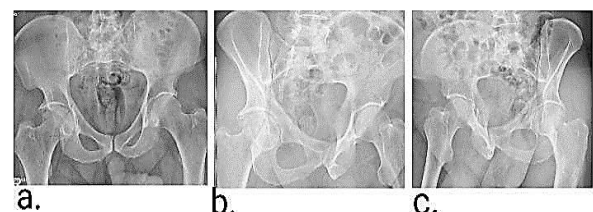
Radiographic images of transverse fracture pattern in both columns from our case; a) Anteroposterior (AP) view; b) Obturator oblique view; c) Iliac oblique view
